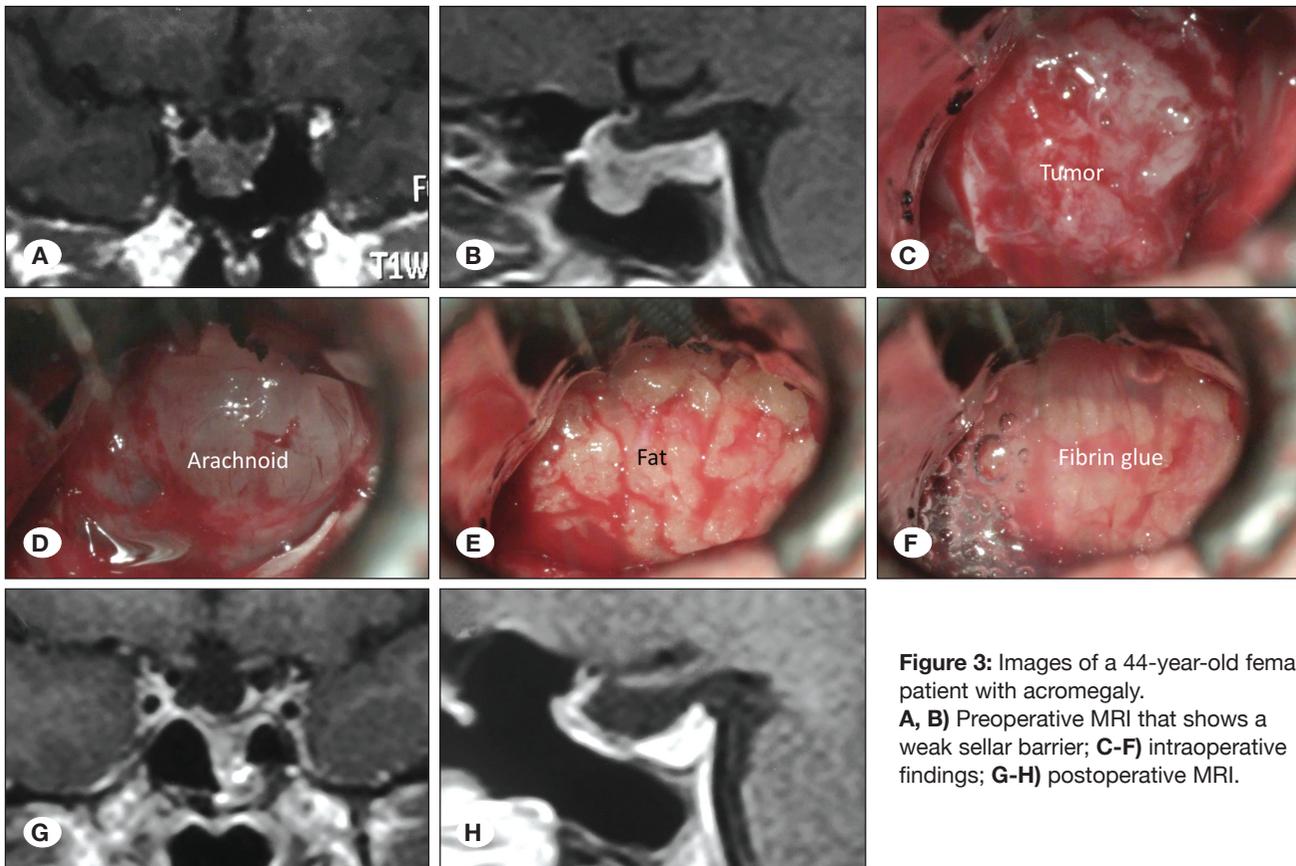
Images of a 44-year-old female patient with acromegaly. A, B) Preoperative MRI that shows a weak sellar barrier; C-F) intraoperative findings; G-H) postoperative MRI.
